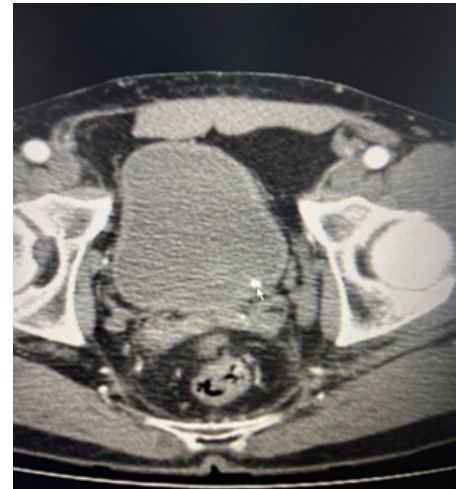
CT scan, deposit at the left ureteral orifice.
